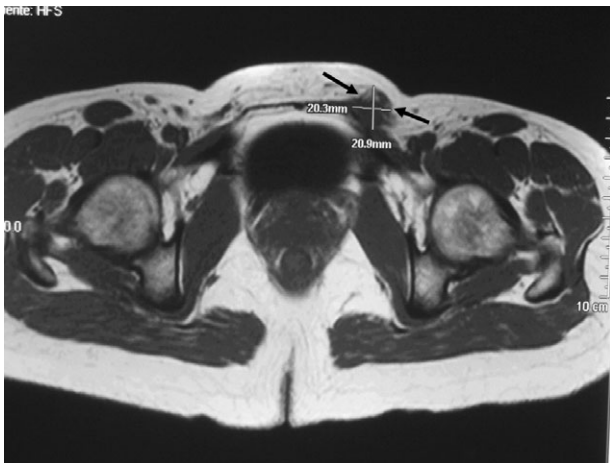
Magnetic resonance imaging scan showing the endometriotic lesion (arrows) of 2 × 2 cm involving the left rectus abdominis muscle.
